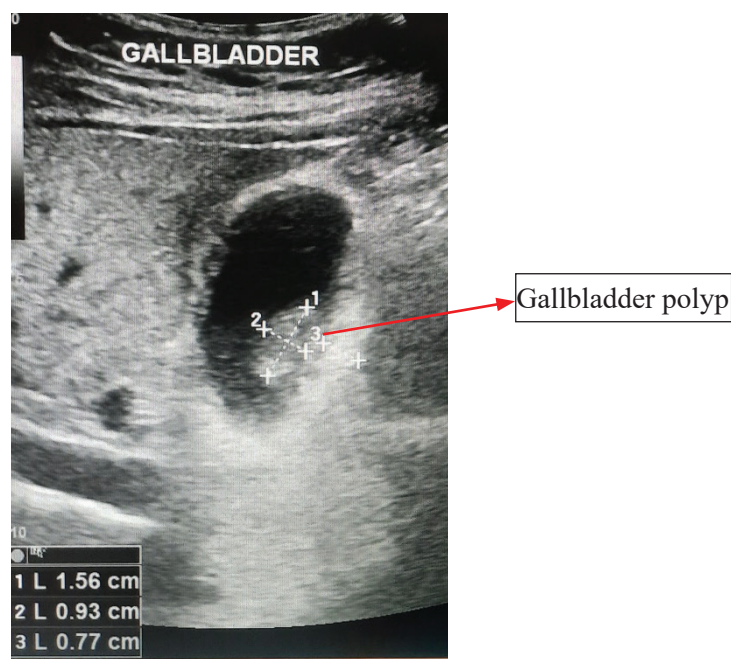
Ultrasonography abdominal (at ER) showed multiple polyps in the gallbladder and no stone
